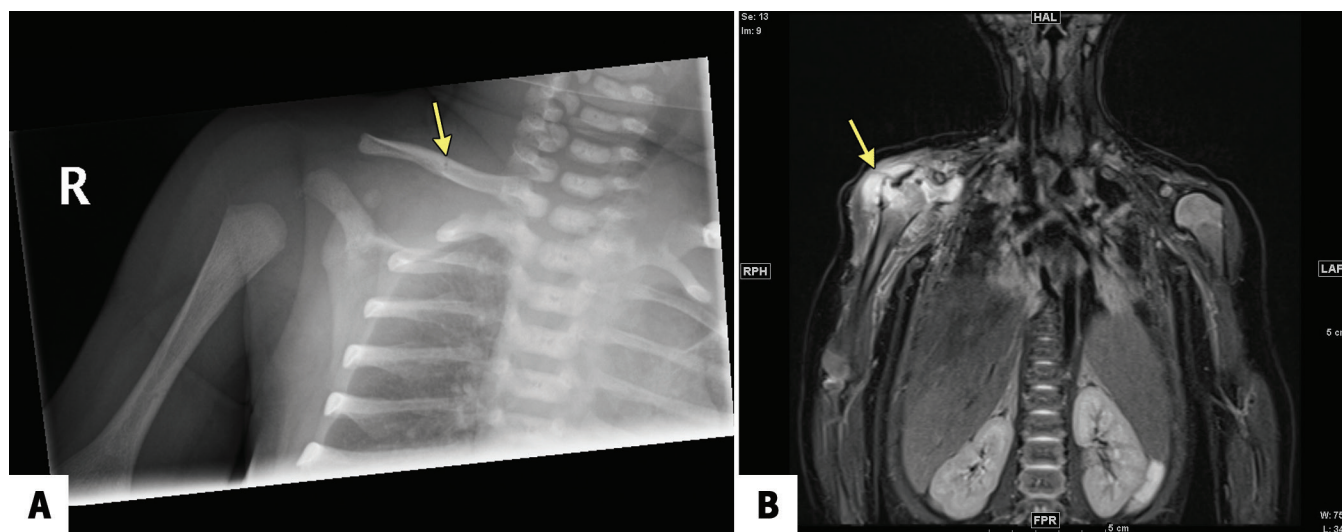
(A) Radiograph of a 10-day-old infant with asymmetric arm movement showing lucency in the midshaft of the right clavicle (arrow), initially interpreted to be a fracture, but subsequently thought to represent a nutrient vessel. (B) Magnetic resonance image showing osteomyelitis of the proximal epiphysis of the right humerus with a small intrachondral collection extending through the joint capsule into the adjacent anterolateral soft tissue. The large right glenohumeral joint effusion with diffuse synovial thickening and enhancement raised suspicion for associated septic arthritis. The image also shows diffuse edema of the surrounding soft tissues and muscles. The arrow denotes the affected arm. The areas of enhancement further highlight the affected tissues.
